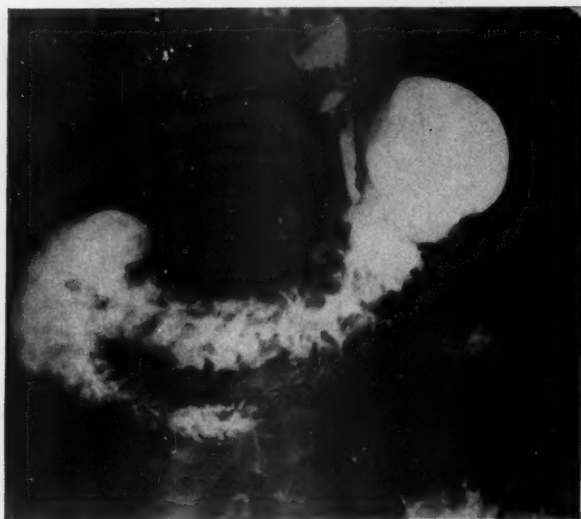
A 10 day roentgenologic study of a cecal pouch taken 10 minutes after the ingestion of barium.
